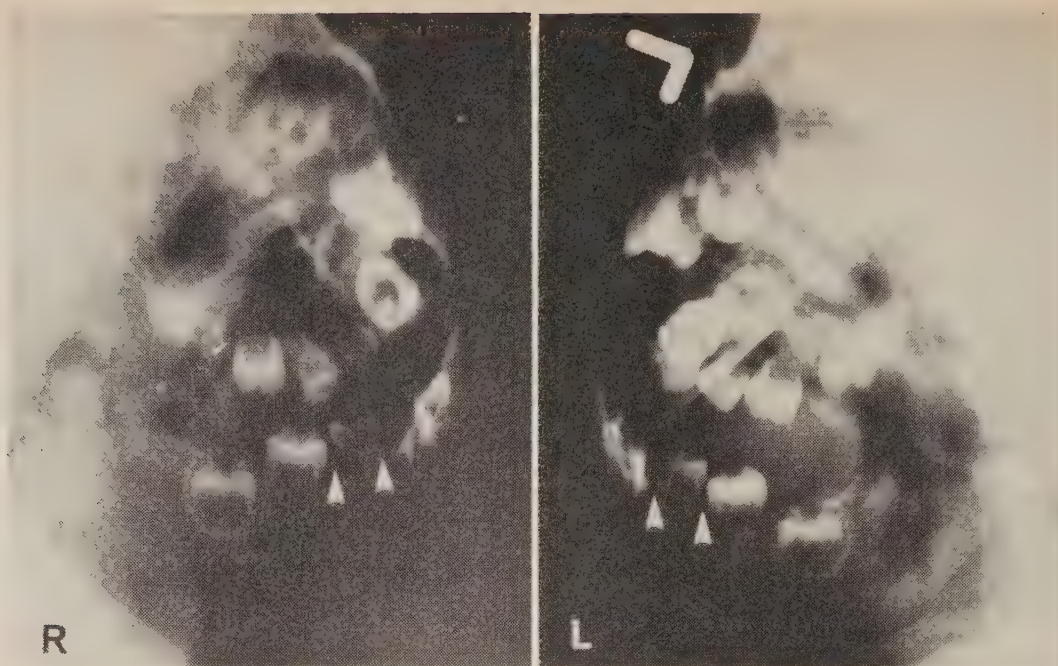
Lateral oblique radiographs of the jaws showing loss of alveolar bone around the primary molars (arrows), resulting in the "floating in air appearance."
